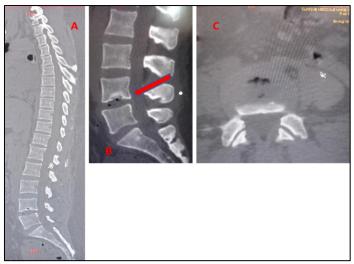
Lumbar CT scan in sagittal (A and B) and axial (C) reconstruction showing only geode of the lower vertebral plate of L4 with narrowing and empty disc L4-L5 and L5-S1 evoking lumbodiscarthrosis
